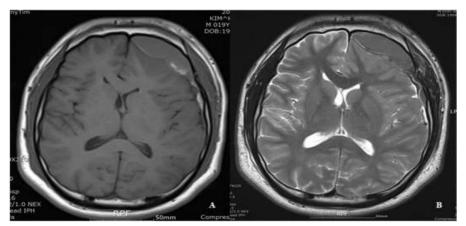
Brain MRI acquired 7 days after trauma revealed an increased amount of EDH, with iso-signal intensity of T1- (A) and T2-weighted (B) axial images
